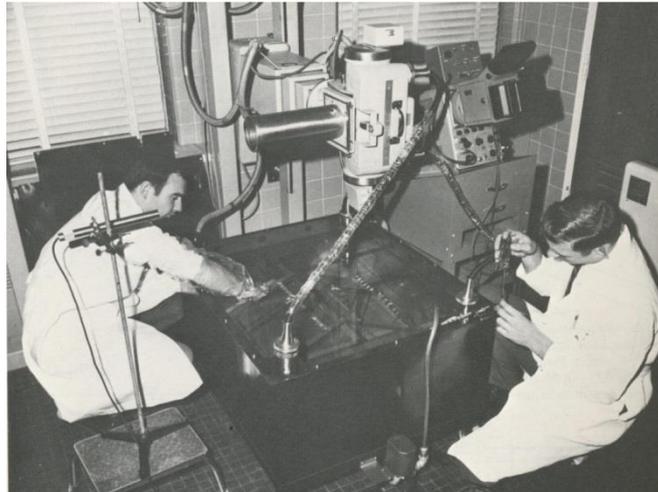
Physicists using a bank of resistors in a tank of insulating oil as an electrical load to evaluate the performance of x-ray generators being developed for mammography
